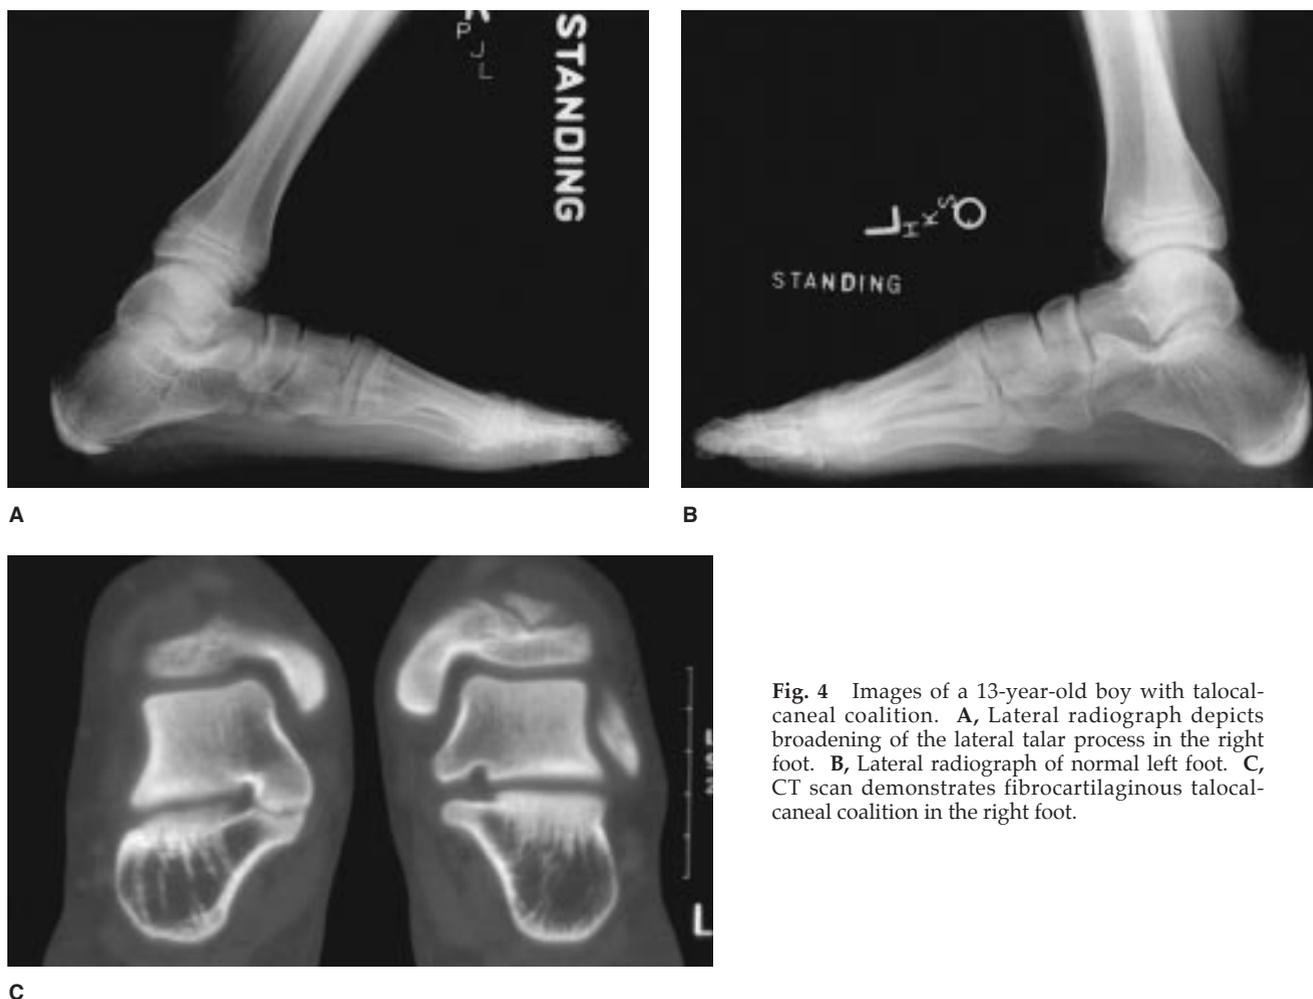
Images of a 13-year-old boy with talocalcaneal coalition. A, Lateral radiograph depicts broadening of the lateral talar process in the right foot. B, Lateral radiograph of normal left foot. C, CT scan demonstrates fibrocartilaginous talocalcaneal coalition in the right foot.
